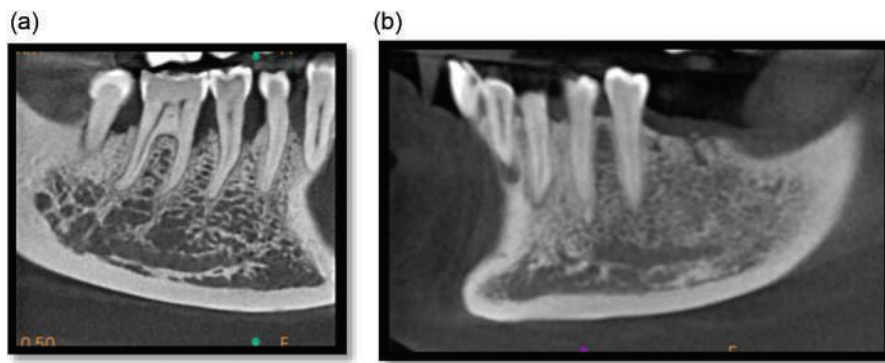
(a) CBCT images depicting T shape of the anterior loop. (b) CBCT images depicting Y shape of anterior loop. CBCT, cone-beam computed tomography
